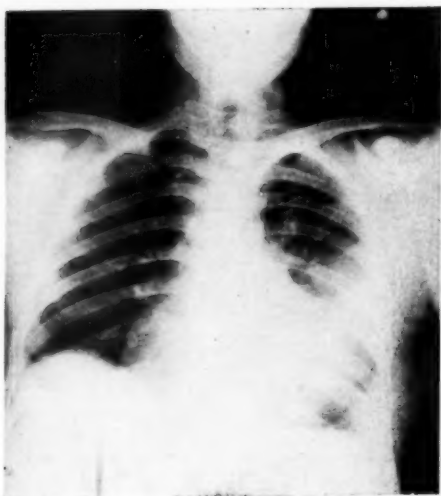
Radiograph of the same patient one week after excision of the empyema.
